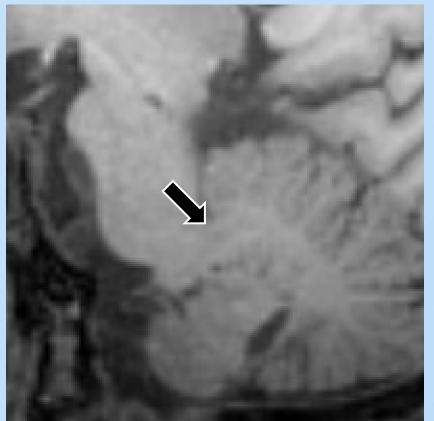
morphometric MRI analysis of brainstem structures showed the following measures: pons area (P), 540 mm<sup>2</sup>; midbrain area (M), 104 mm<sup>2</sup>; middle cerebellar peduncle (MCP) width, 7,75 mm; superior cerebellar peduncle (SCP) width, 3,69 mm. The MRPI value was 10,91.
